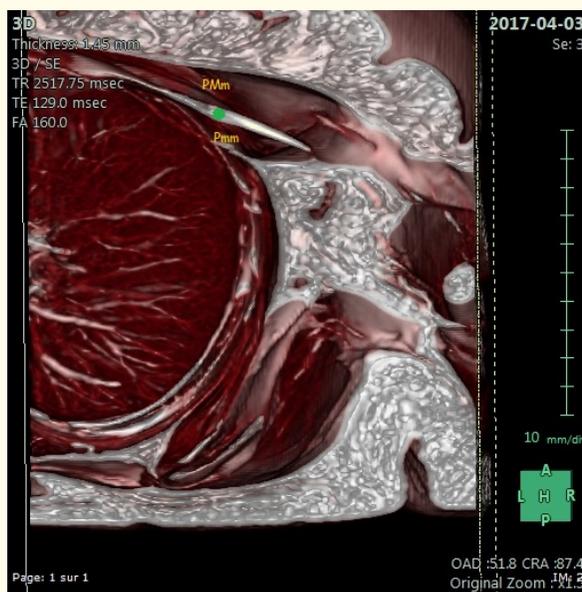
Typical 3D transversal MRI of an interpectoral compartment. The green star identifies the spread of sodium chloride, showing no extension to the axillary compartment. Pm and Pmm represent the pectoralis major and pectoralis minor muscles, respectively.
